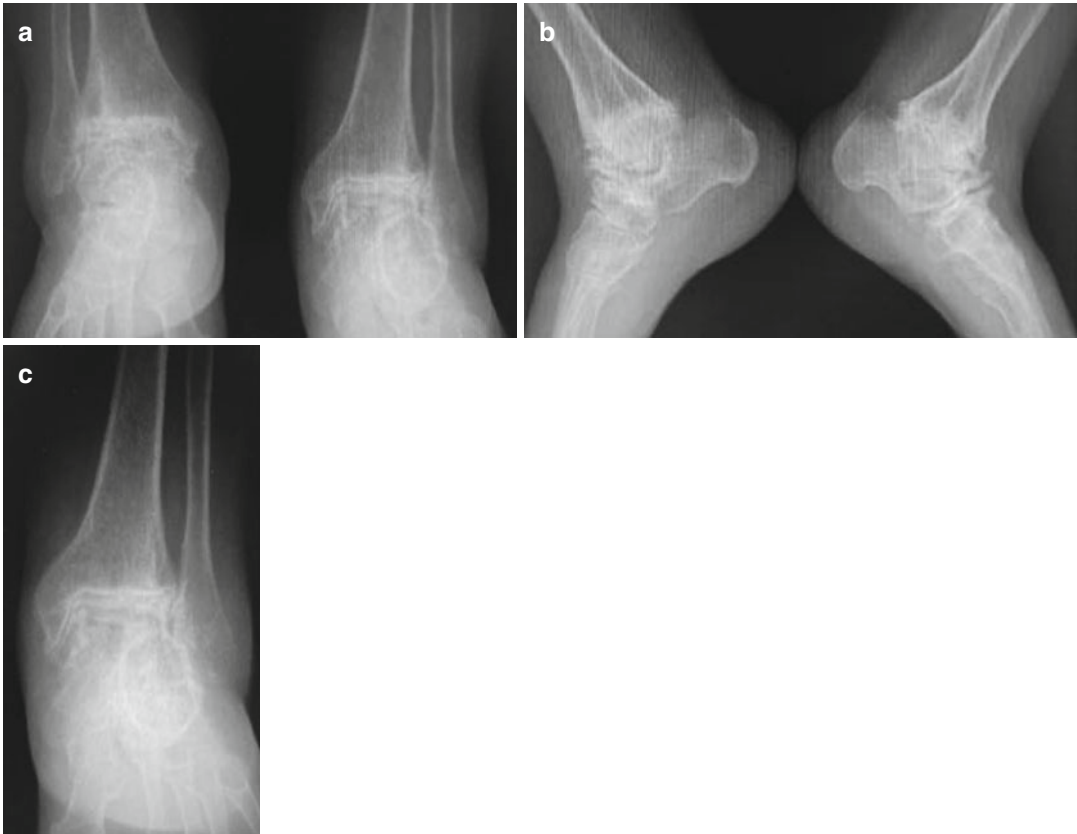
(a–c) Ankle joint narrowing and degeneration on AP (a) and lateral radiographies (b)
